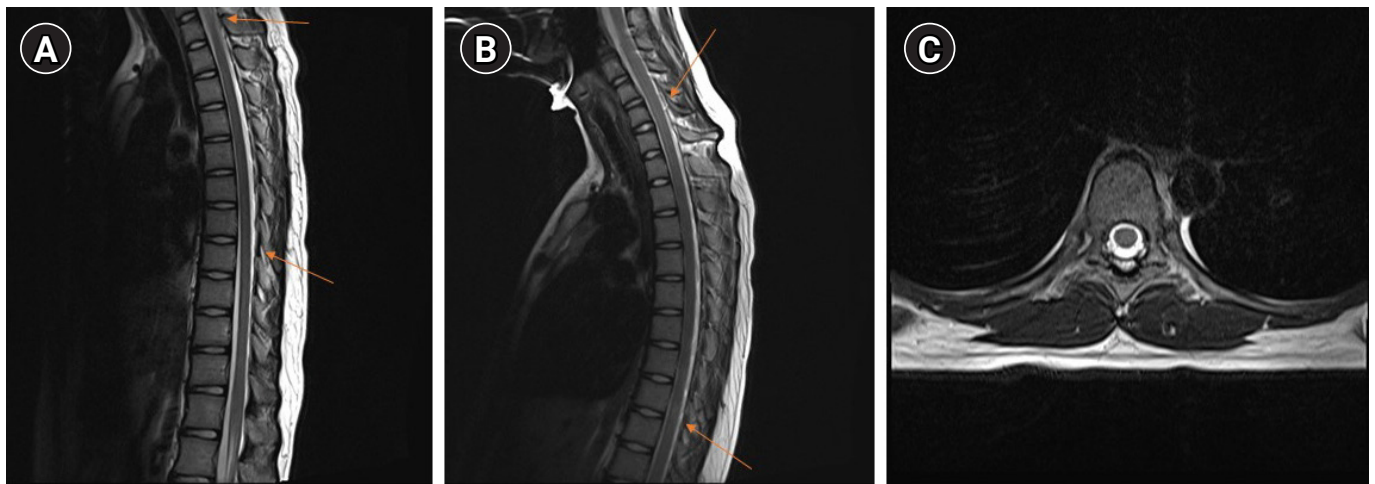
(A) Cervical magnetic resonance imaging (MRI) in the neutral position revealed an enlarged posterior epidural space with epidural venous plexus engorgement (arrows) and enhancement at the C-T junction to the T8 level. (B) Cervical MRI with neck flexion showed prominent posterior epidural vessels (arrows). (C) Axial T2-weighted MRI in the neutral position.
